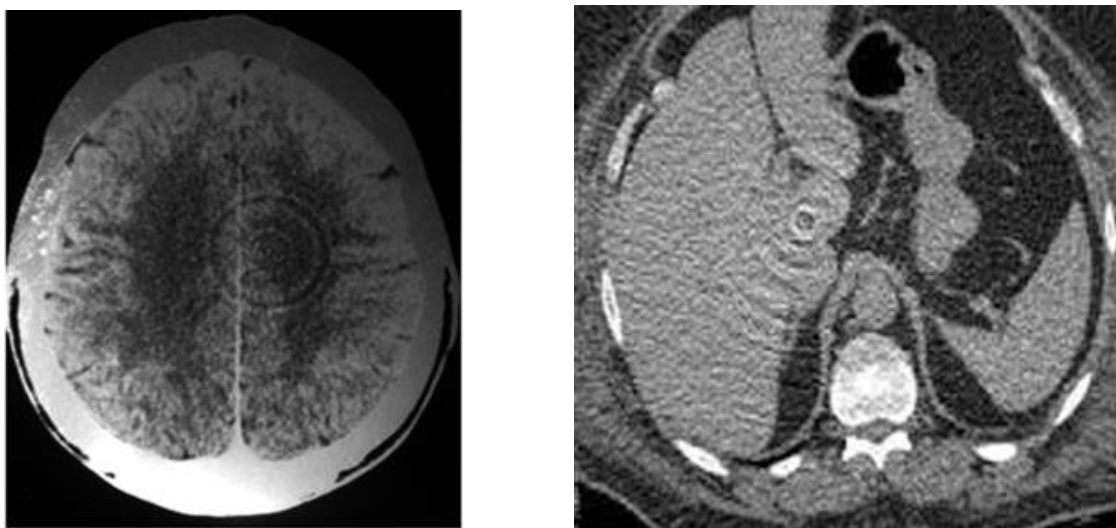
3rd Ring artifact due to malformation of any single detector in third generation CT
